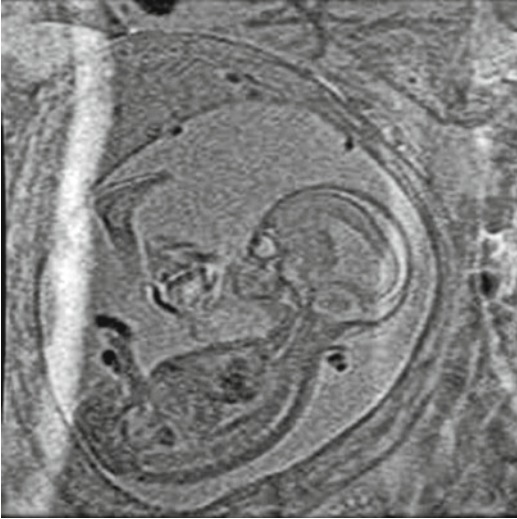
MRI of the fetus showing ventriculomegaly (hydrocephalus) (Courtesy of Bermans Iskandar, M.D., Director of Pediatric Neurosurgery, University of Wisconsin Madison, WI)
